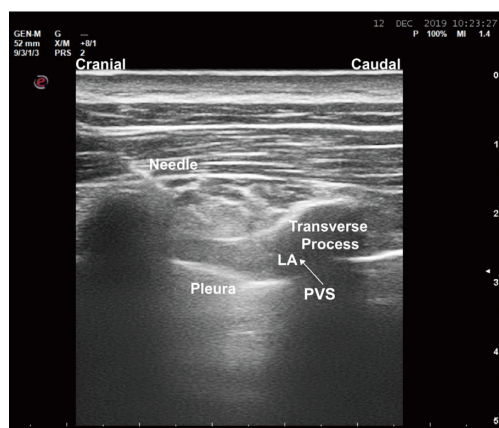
Ultrasound image of TPVB. PVS, paravertebral space; LA, local anesthetic; TPVB, thoracic paravertebral block.
